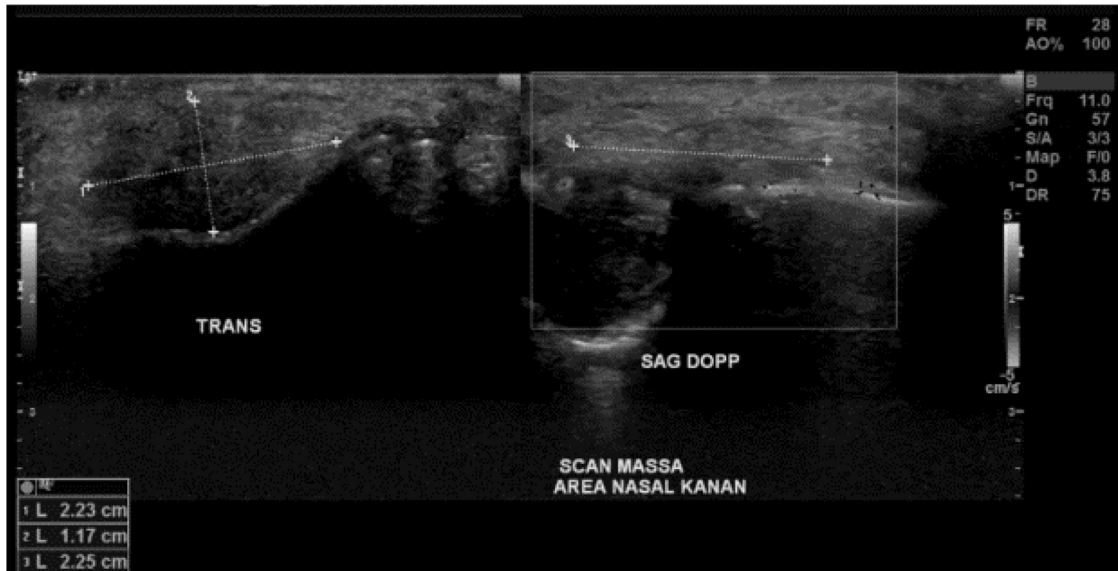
The ultrasound examination identified a heterogeneous mass accompanied by a posterior anechoic lesion, suggestive of cerebrospinal fluid.
